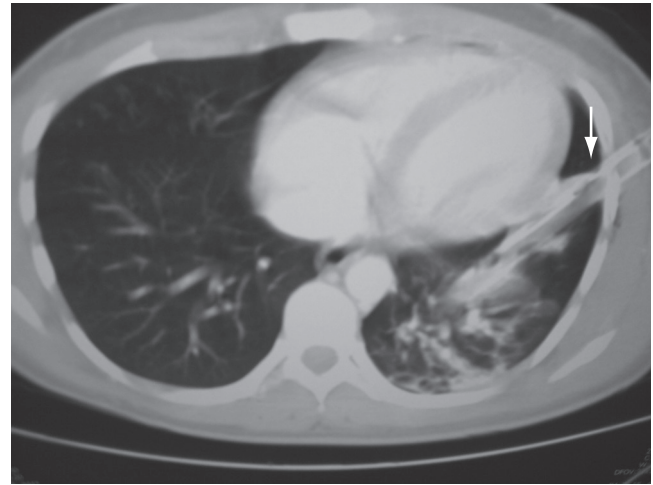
Penetration of lung parenchyma by tube thoracostomy (arrow), with large residual pneumothorax, visible on computed tomography (CT) scan.
